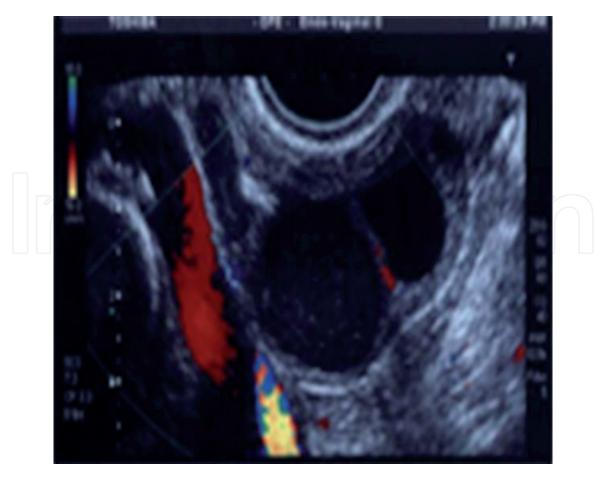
Ultrasound image showing large endometriomas.
